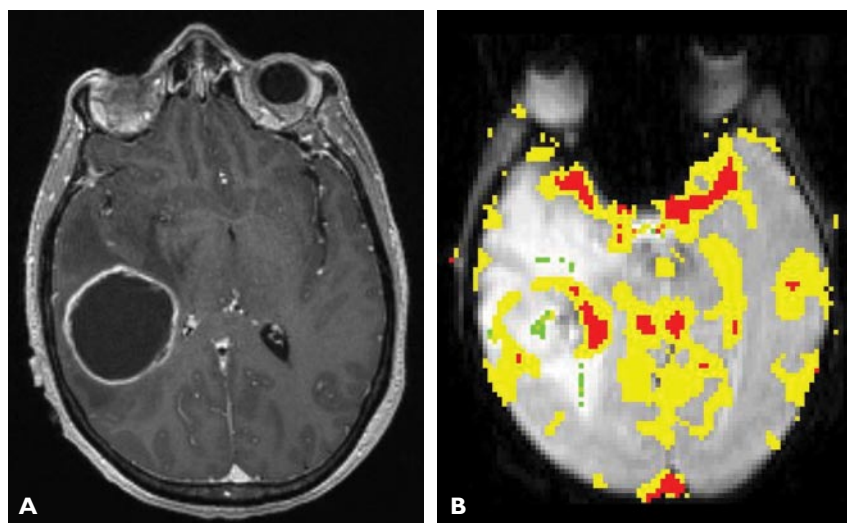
(A) Post-contrast T1-weighted axial magnetic resonance image (MRI) of a patient who underwent resection of a right temporal glioblastoma multiforme tumor and adjuvant radiotherapy. (B) Perfusion-sensitive, contrast-enhanced MRI displaying hyperperfusion and high relative cerebral blood volume at the margin of the resection cavity, which allow active tumor to be differentiated from radiation necrosis.
